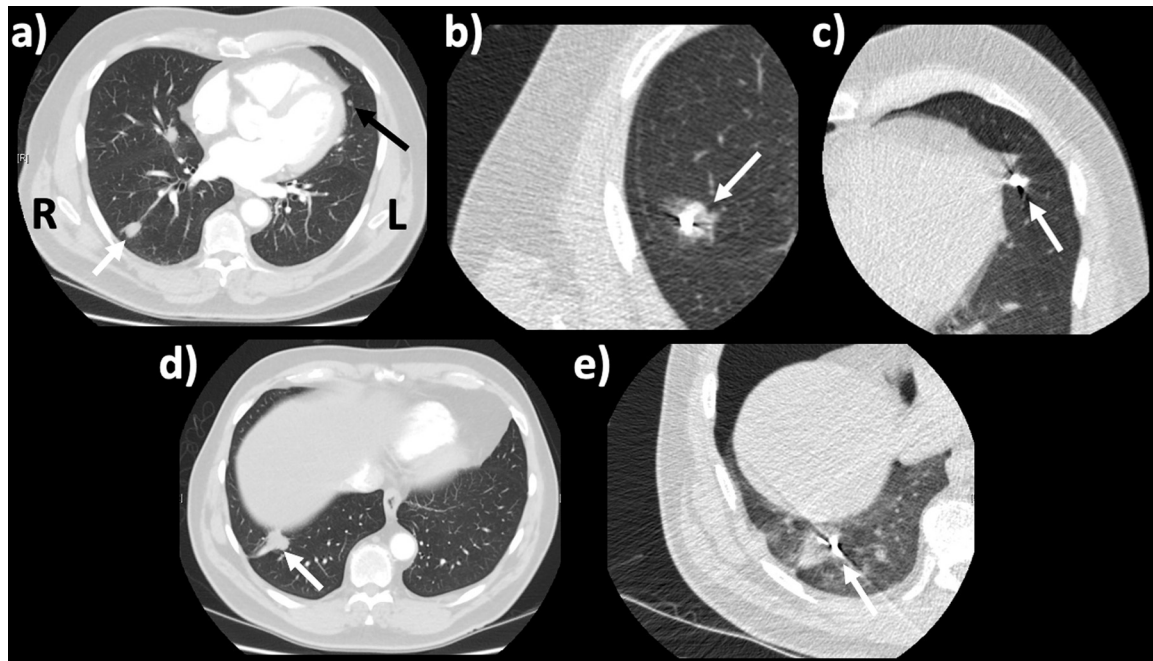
CT guided microwave ablation performed on March 28, 2018. (A) Pulmonary lesions located at the lateral middle lobe and the left upper lobe near the cardiac apex. (B) Right middle lobe lesion received 75 watts for 90 seconds. (C) Lesion near the cardiac apex received 45 watts for 90 seconds. (D) Right lung base lesion appears to be local recurrence. (E) Right lung base lesion targeted with 100 watts for 3.5 minutes.
